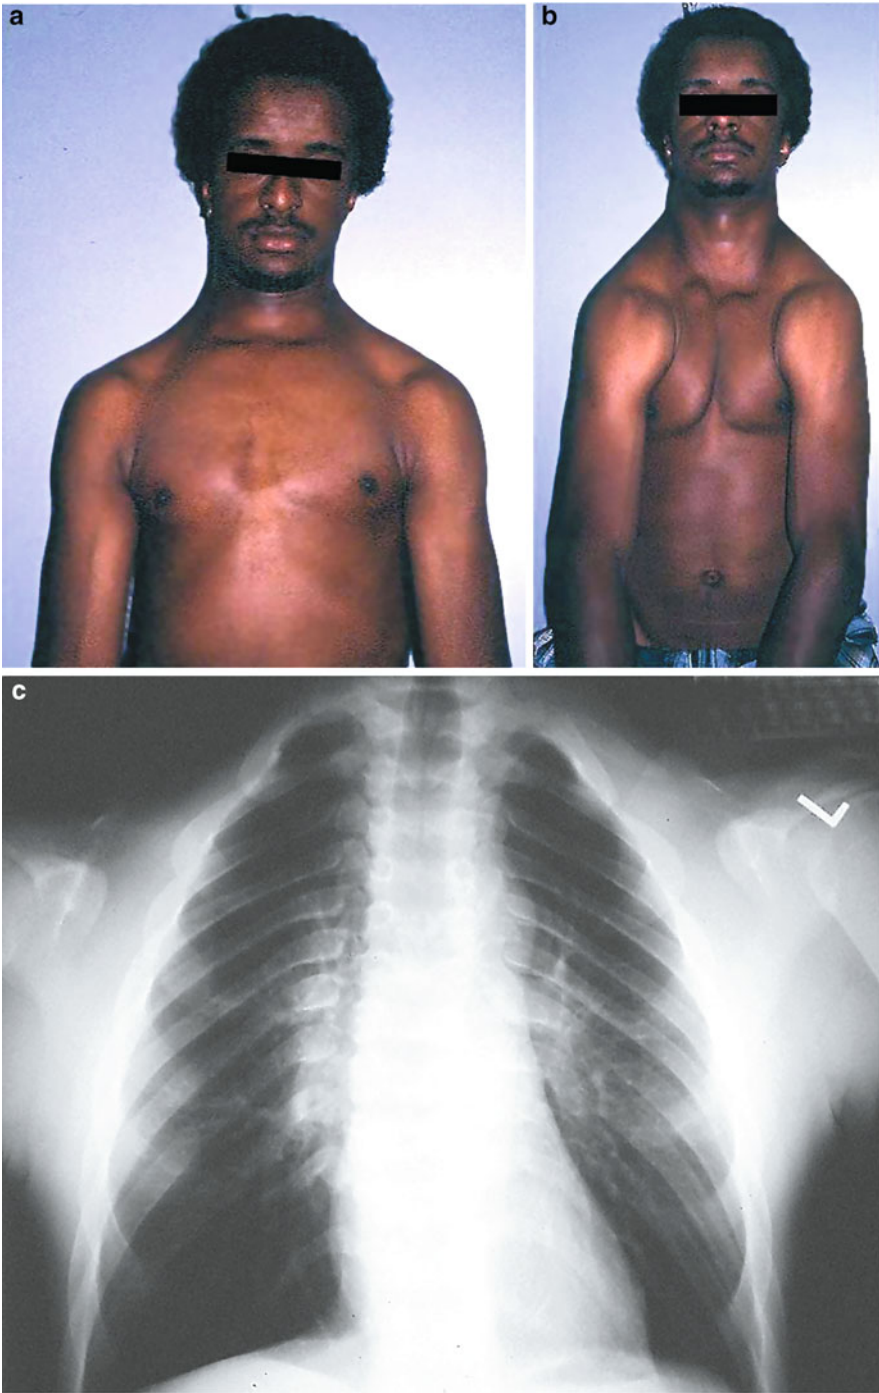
(a–c) An adult with cleidocranial dysplasia showing widened cranial sutures, a characteristic face, and sloping and easily proximated shoulders. Radiograph showed a cone-shaped thorax with absent clavicles
